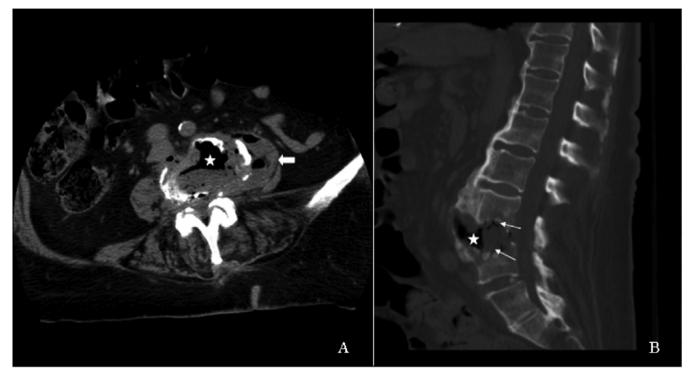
Computed tomography images of an axial section of a soft-tissue window on the L4-L5 disk (A) and a sagittal section of a bone window (B) are shown. A large central gas bubble (white star), erosions of the endplates (thin arrows), and fluid collection with a gas bubble in the left paraspinal soft tissues (wide arrow) are indicated.
